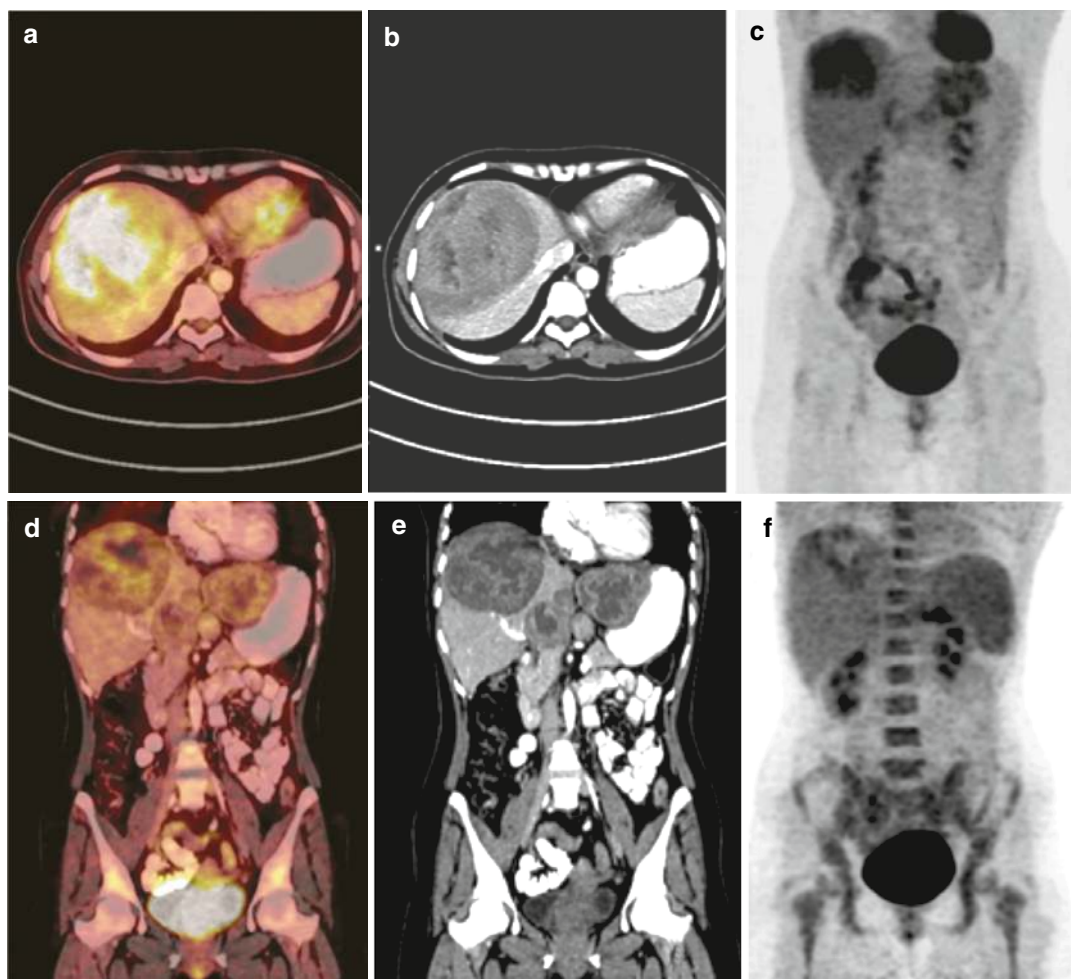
Mild metabolic activity seen in the fused images a and d corresponding to the CT images b and e which shows uptake in images c and f suggestive of the benign lesions—hepatic adenoma
